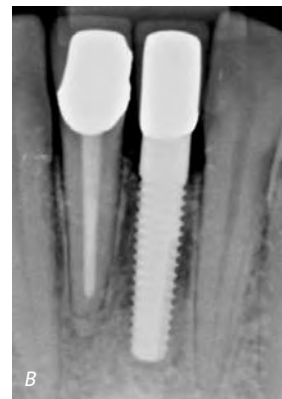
A, One piece implant with crown; B, completed radiograph
